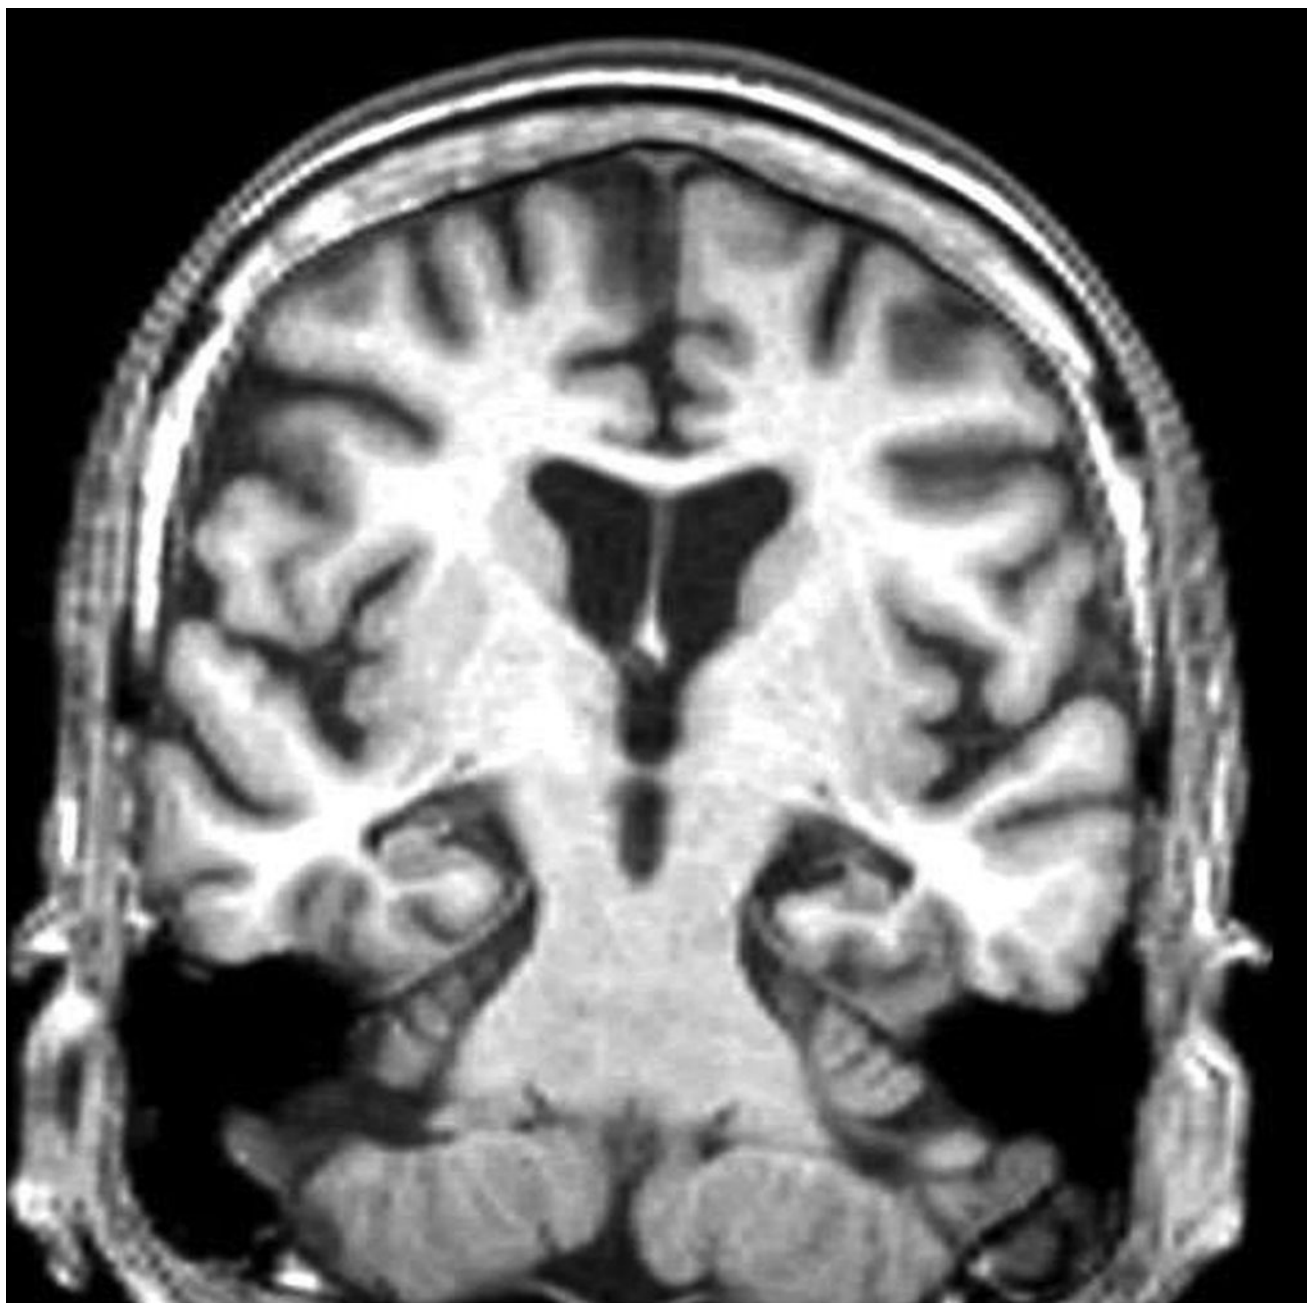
Coronal T₁-sequence magnetic resonance image through the hippocampal region in a patient with mild Alzheimer disease (MMSE=20).
